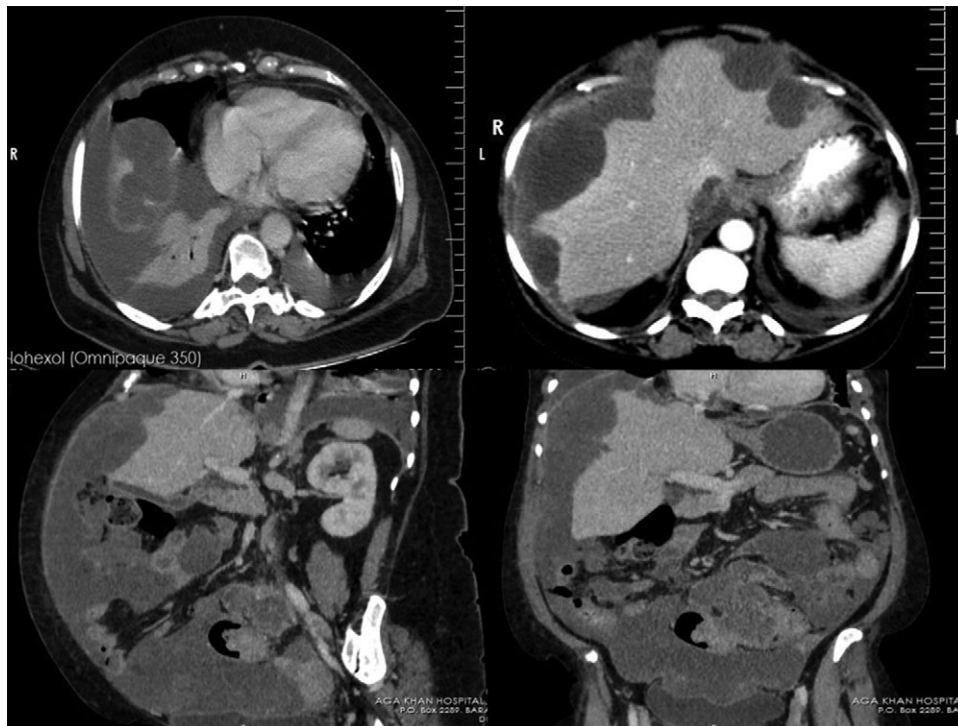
CT scan of the abdomen revealed multiple subcapsular lesion, peritoneal deposit and large ascites (shown via arrow).
